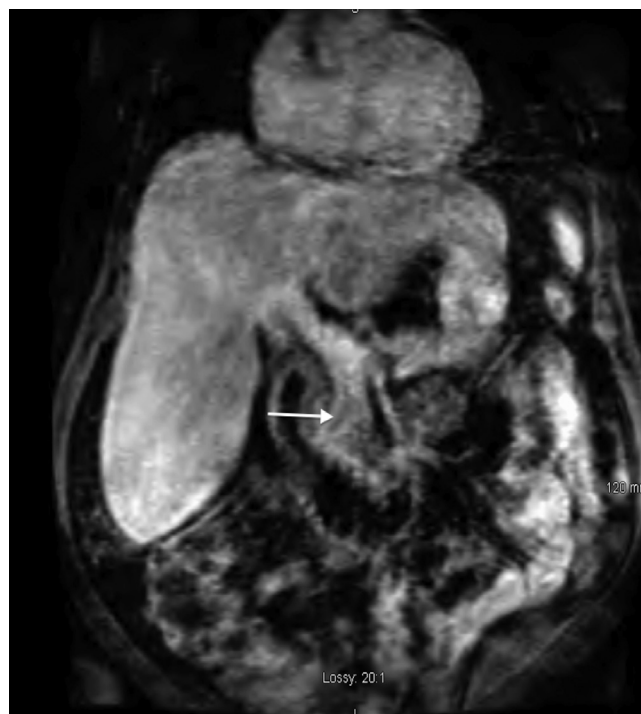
T1-weighted coronal magnetic resonance imaging of the abdomen showing thrombus within the distal superior mesenteric vein just below the confluence of the portal vein (arrow).
